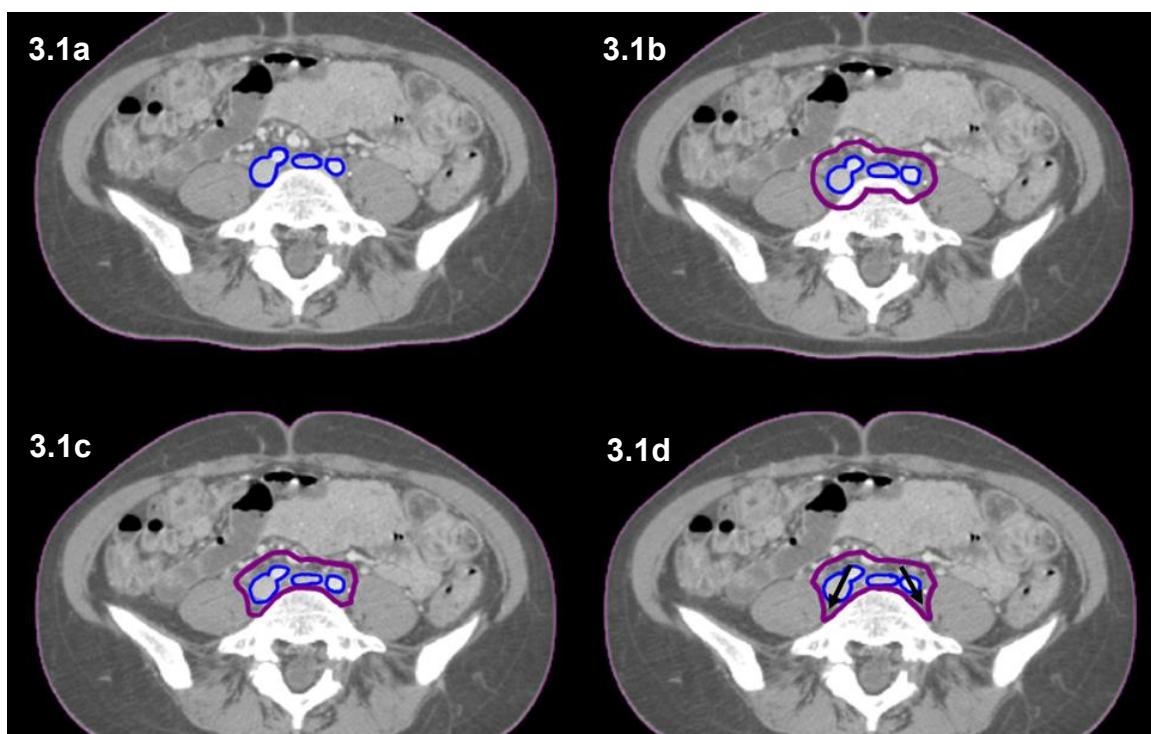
(a) Axial CT image 1cm inferior to aortic bifurcation with common iliac vessels (blue). (b) 7mm margin added (purple). (c) edited to exclude muscle and bone. (d) extended posterolaterally to include area between psoas muscle and vertebral body (arrowed)
